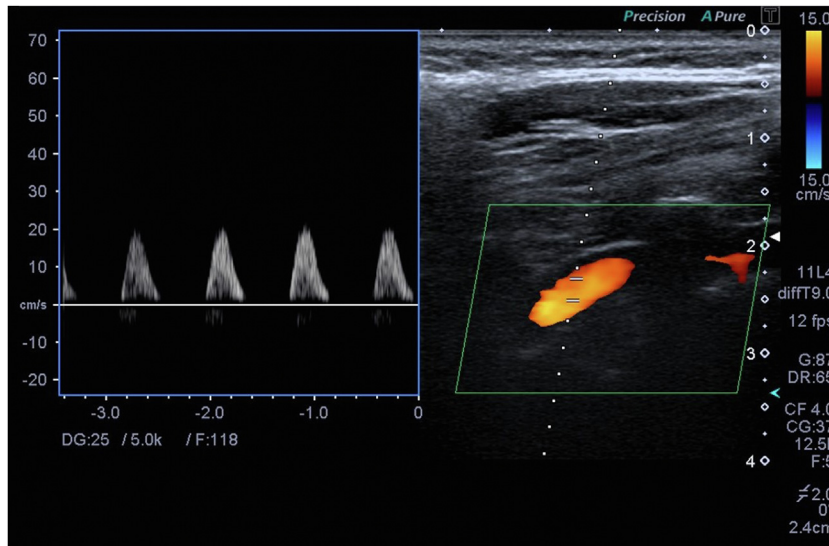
Color Doppler ultrasound showing reversal of blood flow in the left vertebral artery.
